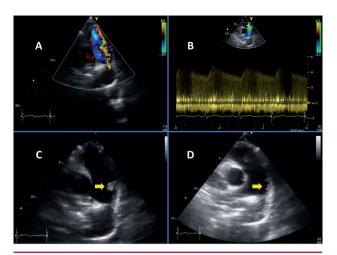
A. Main pulmonary artery. Doppler color image shows blood flow corresponding to a patent ductus arteriosus coming from the left pulmonary artery. B. Spectral Doppler signal showing continuous flow through the patent ductus arteriosus. C. Main pulmonary artery. A 15 mm-long multilobed mobile vegetation is seen on the vessel wall in the area where the blood jet coming through the ductus is impacting (*arrow*). D. Echocardiography during antibiotic therapy. The size of the vegetation has dramatically decreased (*arrow*) as a result of detachment and subsequent pulmonary embolism.
